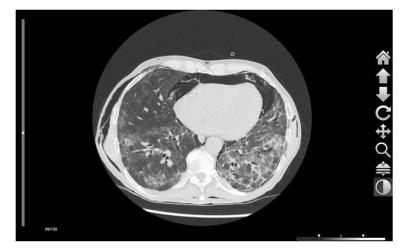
Computer tomography (CT-Scan) of the chest revealed diffuse bilateral ground-glass opacities, poorly defined centrilobular nodules, and mosaic attenuation.
